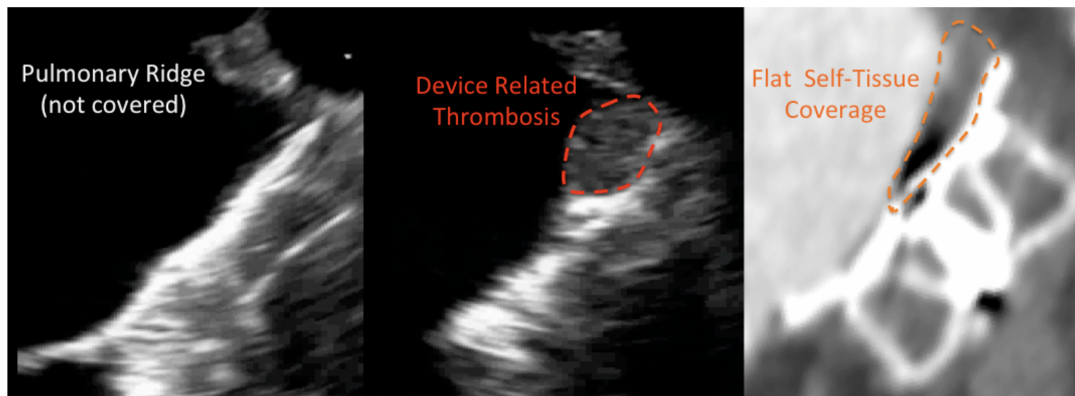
Generation and evolution of device related thrombosis. Device positioning showing the absence of pulmonary ridge coverage (left); recurrent device-related thrombus (DRT) location below the pulmonary ridge (center) and potential endothelization of the DRT area by angio-CT (right).
